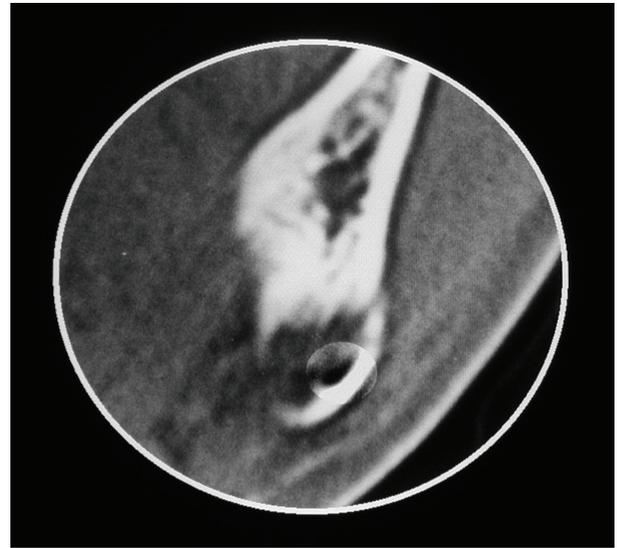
CT image: bone window and coronal view, in which the buccal location of the mandibular canal can be seen.
